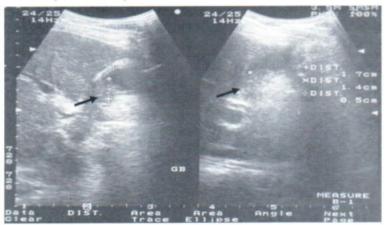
Chronic cholecystitis. Ultrasound demonstrates contracted gallbladder with localized thickening of gallbladder wall (arrows). Gallstone is not identified.
